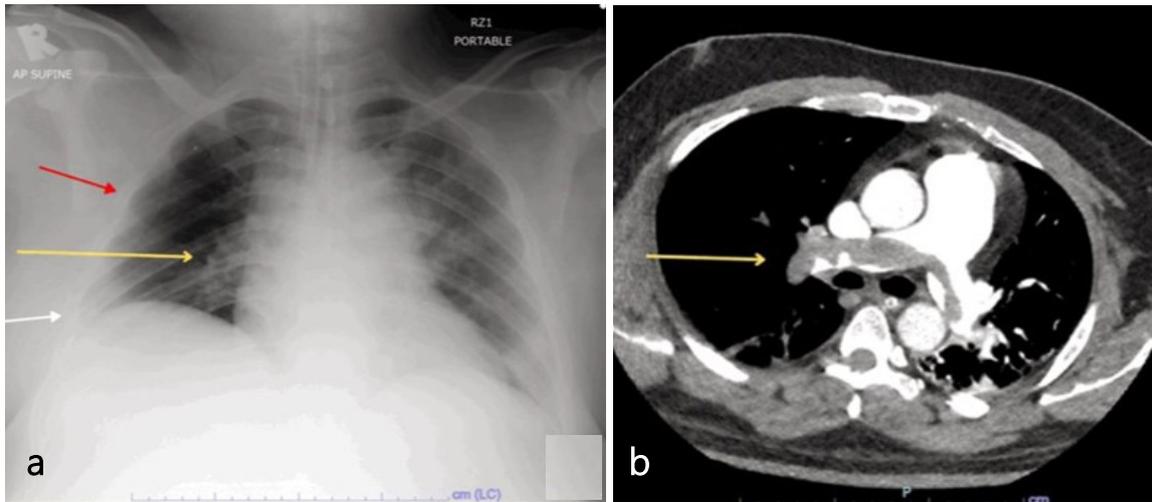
a) Chest radiograph showing: Palla's sign (yellow arrow), peripheral wedge opacity (red arrow) and focal oligemia (white arrow), b) Axial CT pulmonary angiography demonstrating a right pulmonary artery embolus (yellow arrow).
